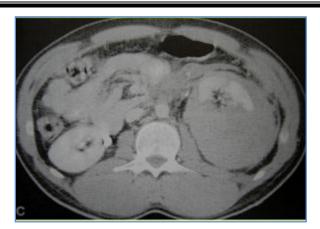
Contrast enhanced CT scan showing Left renal grade 5 injury with splenic laceration
